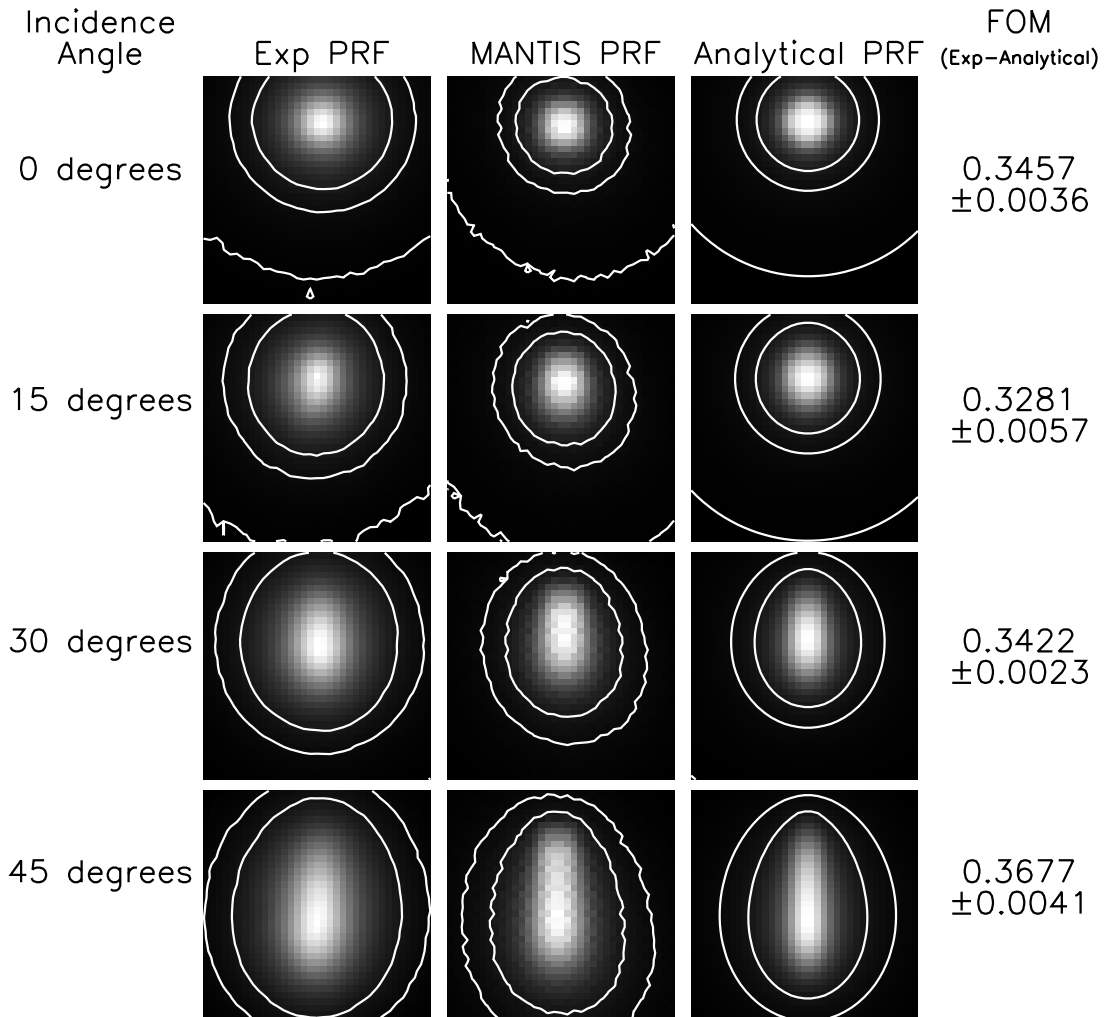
Comparison of the analytical model with experimental PRFs. The experimental data were taken at 40 kVp (25.6 keV mean photon energy) with a 170 μm thick CsI scintillator and a 30 μm pinhole. The analytical model was convolved with a 30 μm incident beam profile and then fit to MANTIS data that was generated by taking into account all the details of the actual CsI screen geometry. The MANTIS data was generated with a 100 μm diameter pencil beam incident on a 30 μm pinhole. The incidence angle of the incoming x-ray beam is indicated in the left-most column followed by the corresponding experimental PRFs, MANTIS-generated PRFs, analytical model PRFs, and FOMs from the comparison between the experimental and analytical data. The analytical model was fit to the MANTIS results then a comparison was performed between the analytical model and the experimental data. This procedure was followed as opposed to fitting the analytical model to the experimental data since experimental PRFs will not be available for typical applications. All PRFs are 0.315×0.315 mm with 9 μm pixels. Contours are shown for levels of 0.01, 0.05, and 0.1 times the maximum of the PRF.
